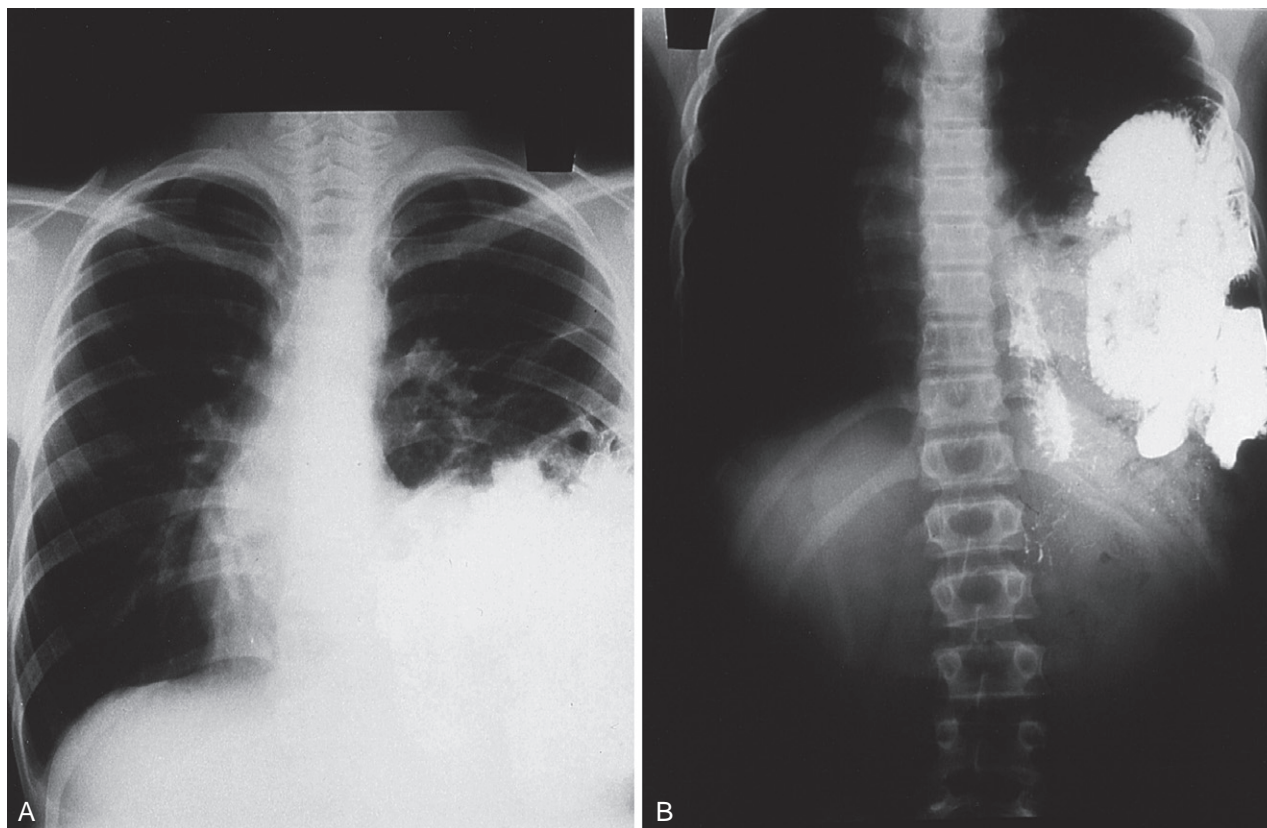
Ruptured diaphragm. A, Plain chest radiograph. B, Herniated bowel on gastrointestinal contrast study.
